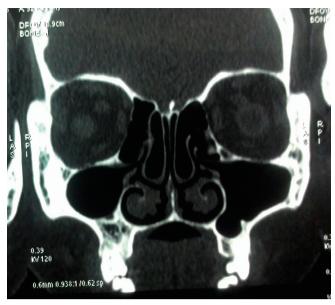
CT scan showing bilateral concha bullosa of middle turbinate.
